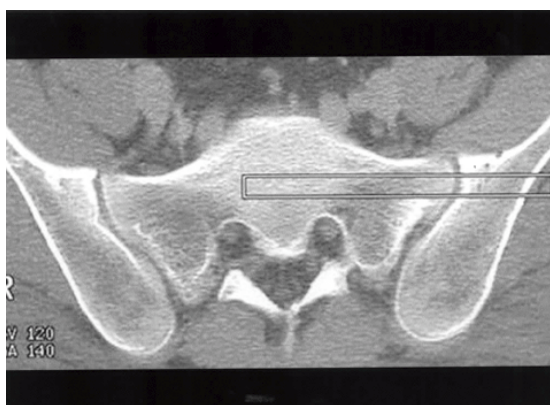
Safe zone for transverse iliosacral 6.5mm screw on CT image. The square represents the 6.5mm screw. 3A. This CT image shows the wide safe zone.
